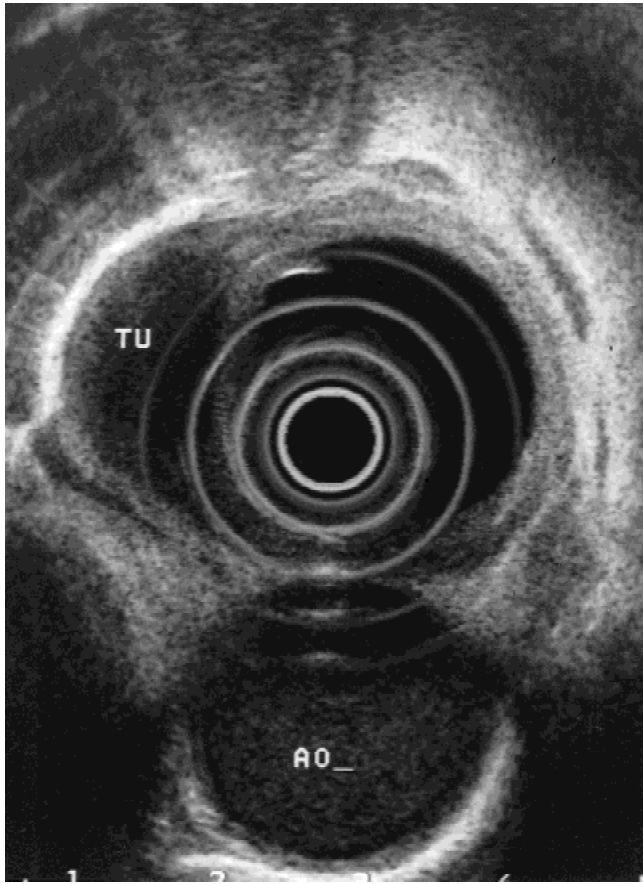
Upper endoscopy with ultrasound demonstrates T1 tumor of the esophagus (TU) at 29 cm. There are no suspicious periesophageal lymph nodes. The descending aorta (AO) is seen posteriorly.
